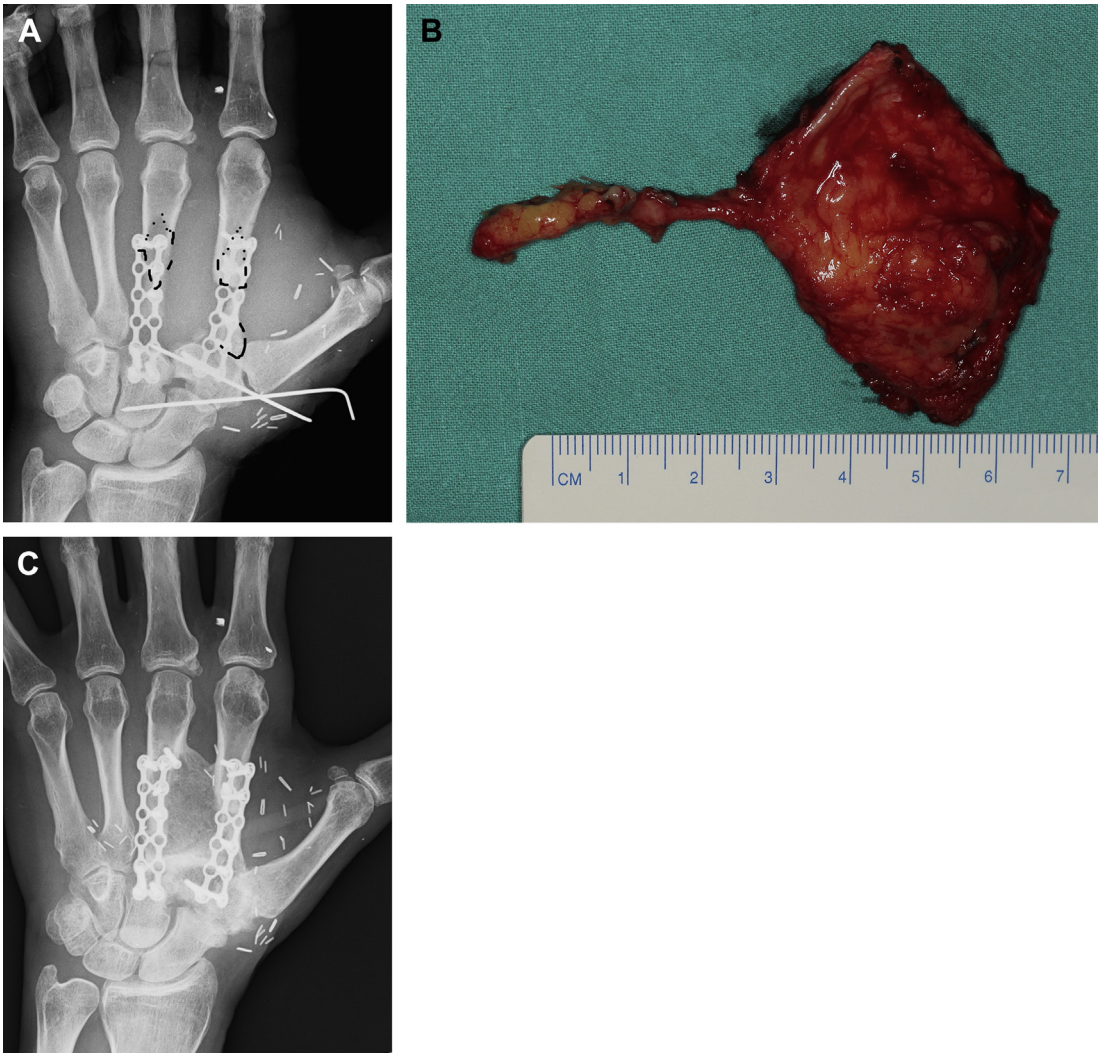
(A) A large defect of two-thirds of the anterior aspect of the second and third metacarpals. The bony lengths were maintained temporarily with locking plates. (B) A 4×3 cm medial femoral condyle corticoperiosteal flap stabilized in place with 2.0-mm screws allowed the authors to span the defect and permitted immediate range of motion. (C) A plain radiograph 7 months after the operation (the same patient as in Fig. 3). (Copyright © 2015, Francisco del Piñal, MD.)
